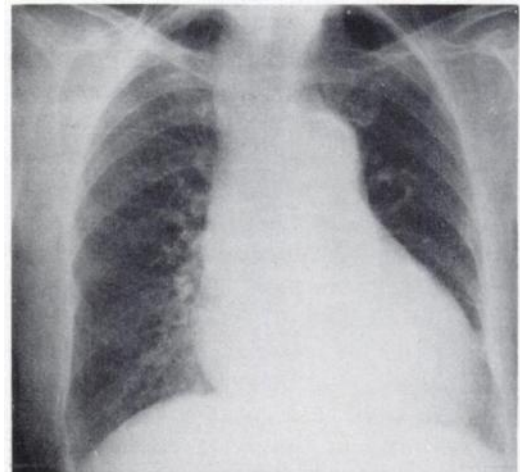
X-ray film of chest showing wide mediastinum due to aortic aneurysm and cardiac tamponade.
